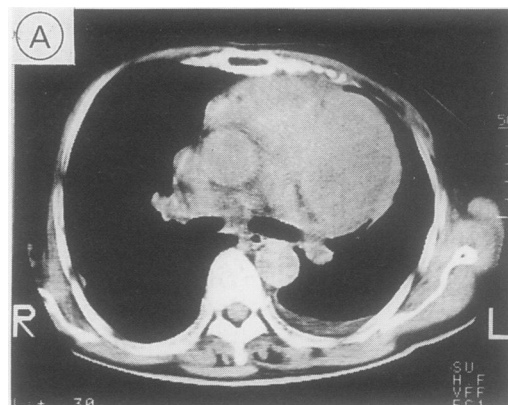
Computed tomogram showing a large, demarcated mass lesion located in the left anterior mediastinum.
